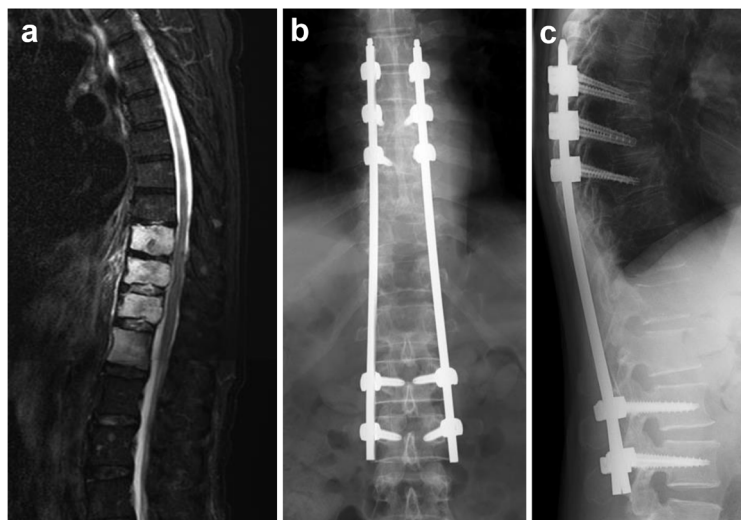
Posterior fixation surgery using percutaneous pedicle screws (PPS) for metastatic spinal tumor (MST). An 82-year-old male with multiple spinal metastases from leiomyosarcoma. (a) Sagittal T2-weighted fat-suppressed MRI image. (b, c) Multilevel posterior fixation surgery using PPS: (b) Postoperative AP X-ray. (c) Postoperative lateral X-ray.
